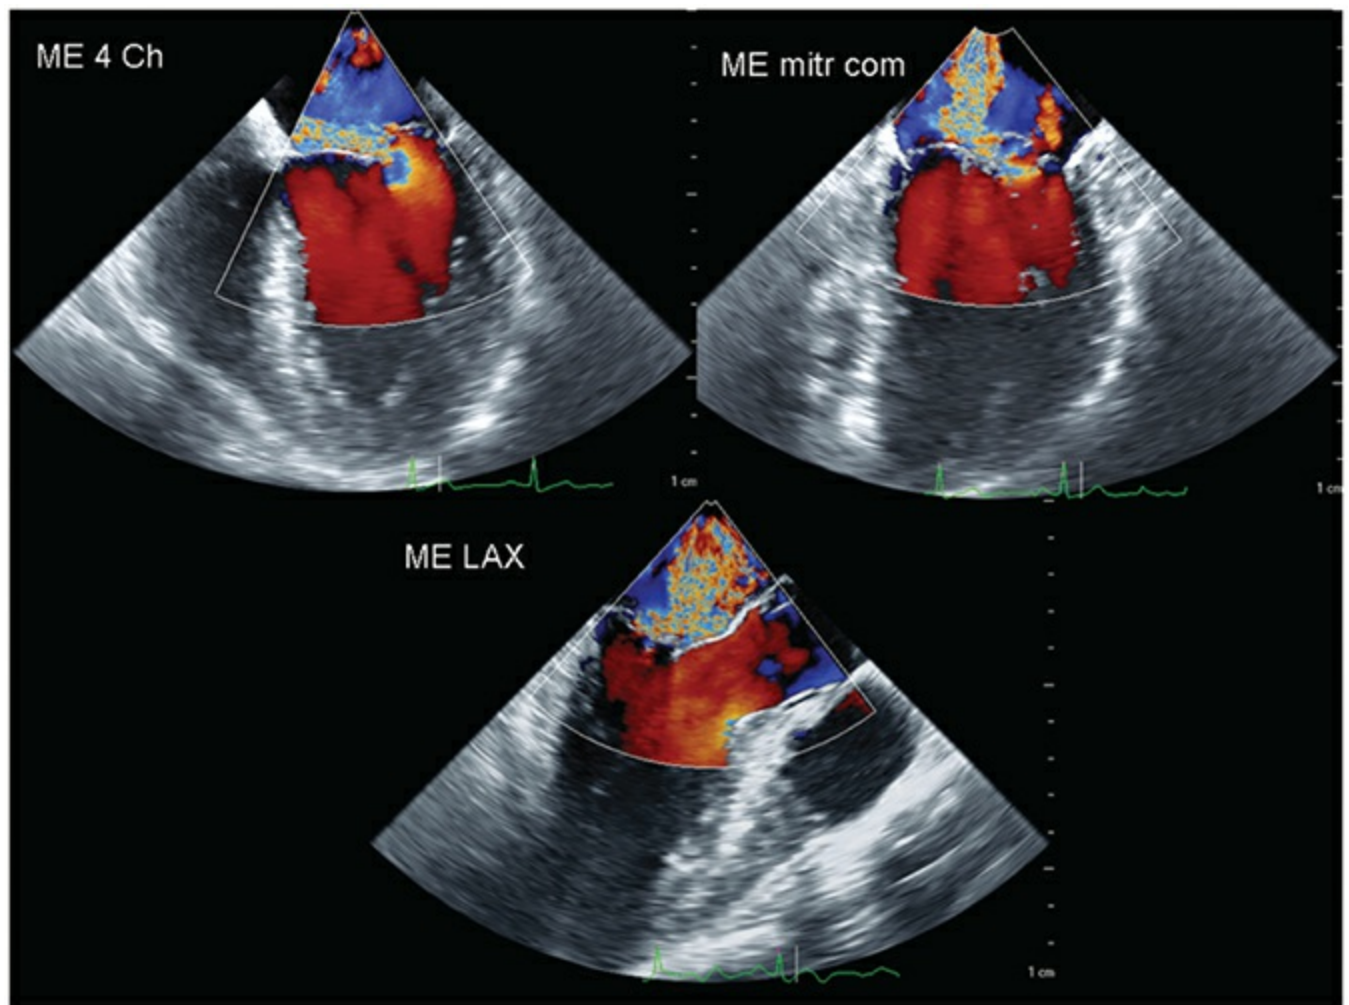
Color flow Doppler of type II regurgitation, caused by excessive leaflet motion, in this case prolapse affecting the P2 segment. The resulting jet is eccentric, and blood is directed over the corresponding, nonaffected (A2) leaflet. ME LAX, midesophageal long axis.
